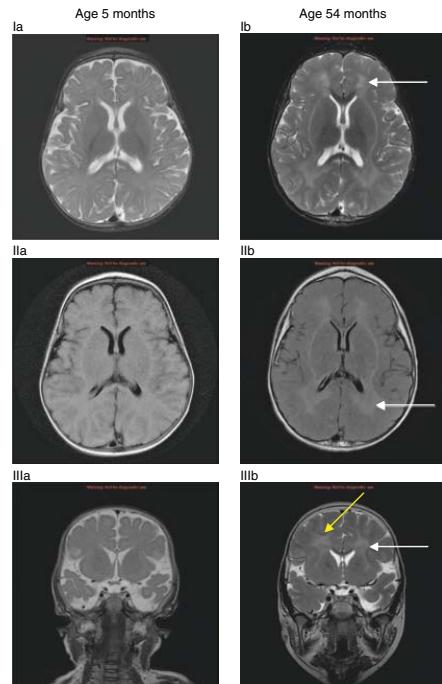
Long-term changes on brain magnetic resonance imaging (MRI) of patient 1. The images on the left, taken at age 5 months, show normal myelination for age. The images on the right, at age 54 months (4.5 years) show development of T2 prolongation within the deep white matter (white arrows) in the periventricular white matter, centrum semiovale, and external capsule, sparing the subcortical U-fibers (yellow arrow) as well as the internal capsule. I: T2 axial scans at ages (Ia) 5 months and (Ib) 54 months; II: T2 fast low-angle inversion recovery (FLAIR) images; III: T2 coronal scans.
